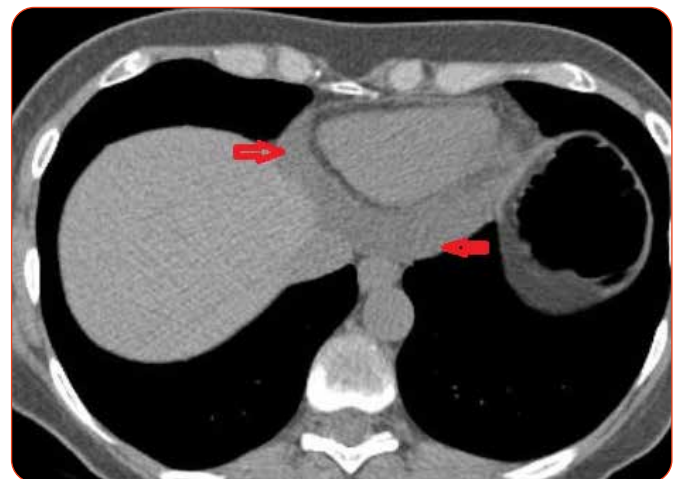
Axial CT scan showing a large pericardial effusion (red arrows).
